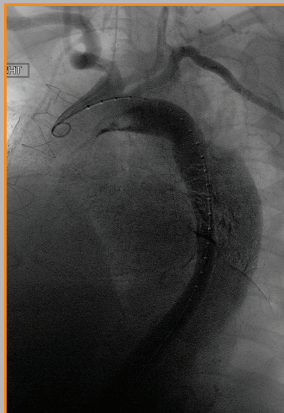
Angiogram preceding TEVAR. A marker pigtail catheter is in the aortic arch and is in the true lumen. This was confirmed via intravascular ultrasound (IVUS) prior to stent placement. The catheter abuts the dissected intima. The false lumen fills laterally (right on image, patient's left).
